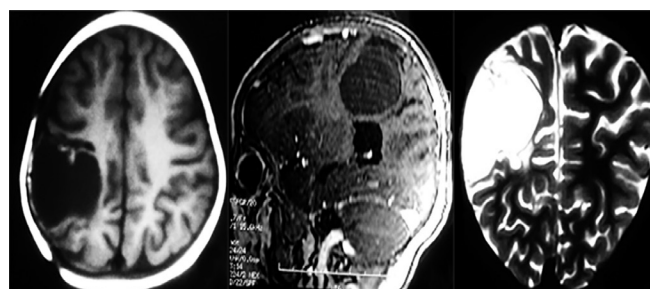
Follow-up magnetic resonance imaging at 20 months (axial T1, sagittal T1 with gadolinium and coronal T2 weighted images) showing complete removal of the lesion without recurrence.
